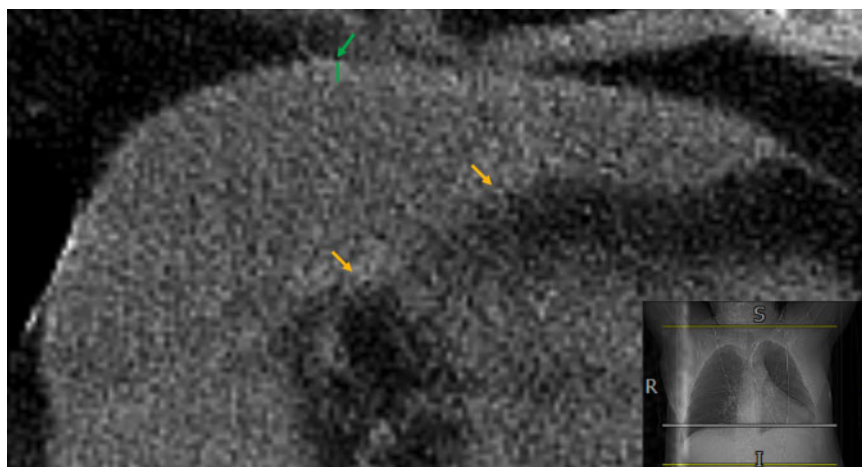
Interval unenhanced computed tomography thorax with soft tissue windowing in axial plane demonstrating the thickened parietal pericardium of 4.8 mm (arrowed green) and distorted cardiac border against the visceral pericardium (arrowed orange).
